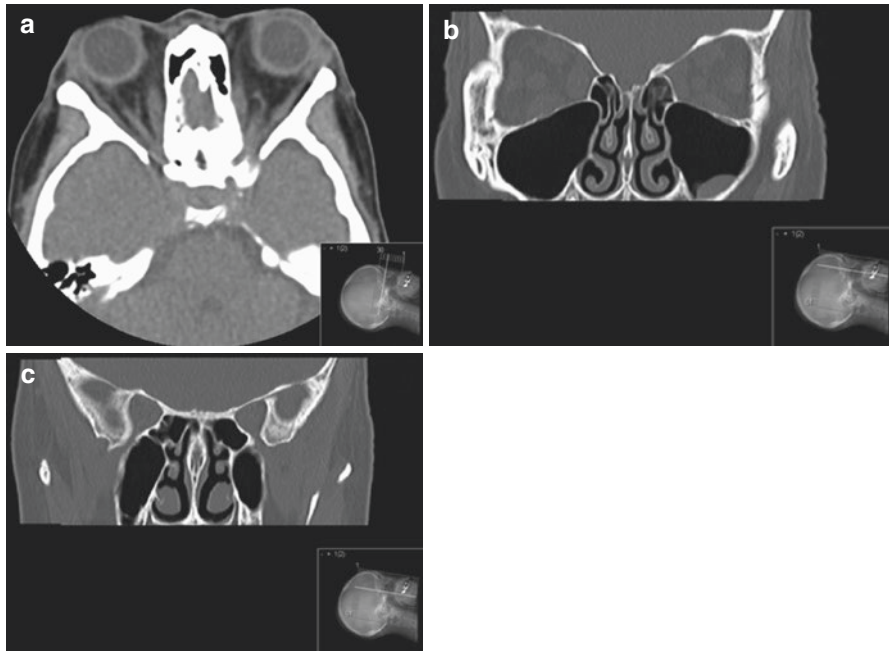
CT scan of orbits: coronal and axial scans (a, b), showing a rather symmetrical bilateral proptosis caused by enlargement of the rectus muscles on both sides, which does not extend anteriorly to involve the tendons, but which does extend back to cause crowding on both sides (c), at the orbital apex on both sides, but worse on the left where compression of the optic nerve may be seen. Inflammatory change is seen within the orbital fat. The lacrimal glands are not enlarged and the superior ophthalmic veins not distended
